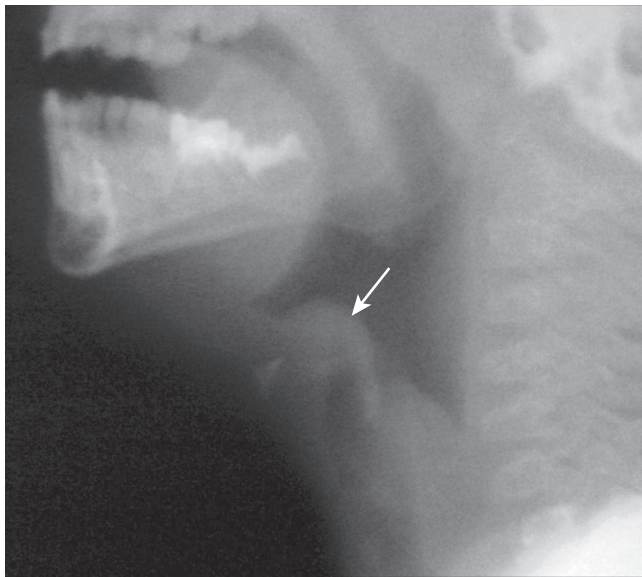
Lateral neck radiograph demonstrating epiglottitis with the “thumb sign.” (From Zaoutis LB, Chiang VW. Comprehensive pediatric hospital medicine. 1st ed. Philadelphia: Mosby, 2007, Fig. 66-3.)
